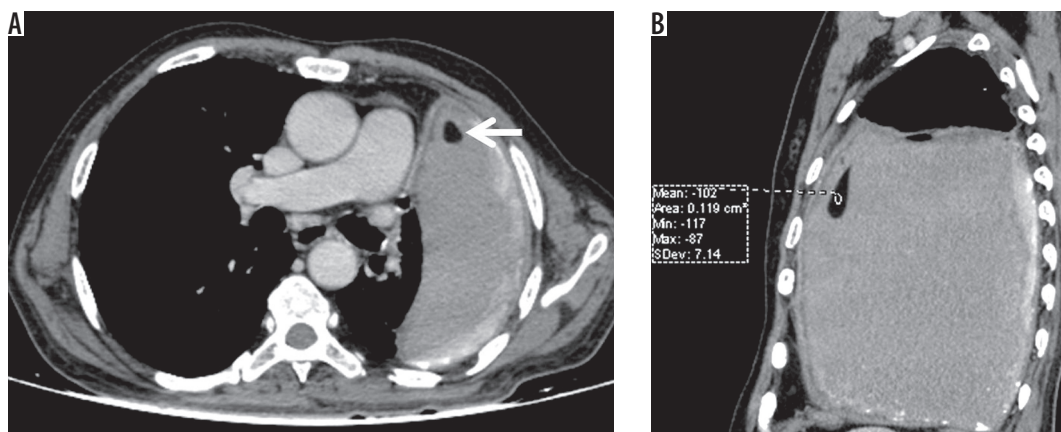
A) Axial (B) coronal post-contrast chest computed tomography image mediastinal window showing left-sided chronic pleural effusion with enhancing smooth pleural thickening and calcification. Fat-fluid level is noted in the pleural effusion (HU: -102). Chylous pleural effusion was noted on pleural fluid evaluation
